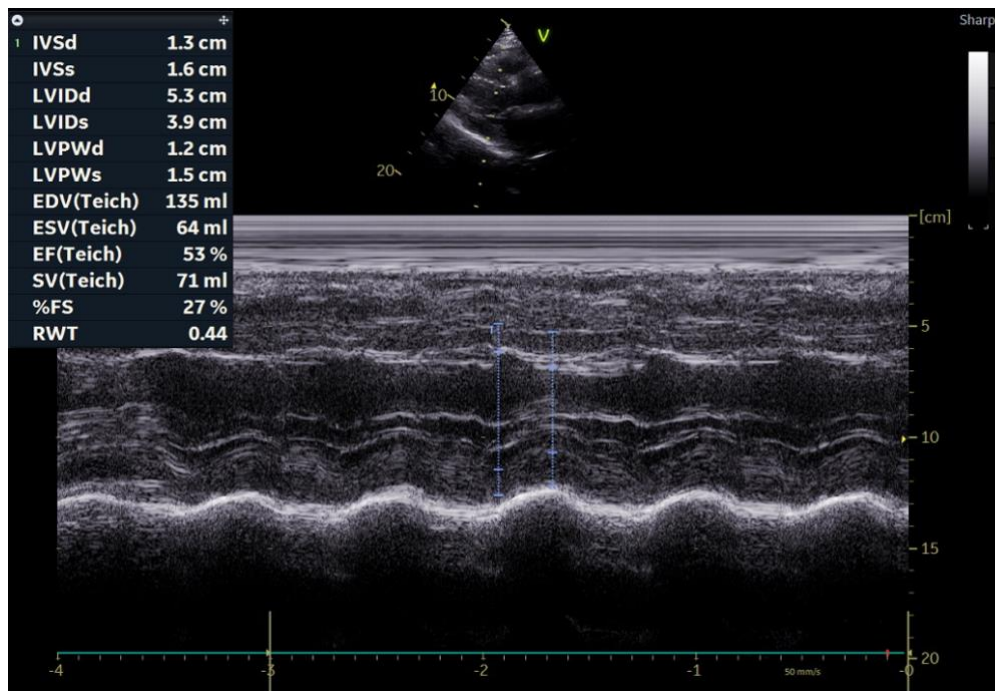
LVIDd, LVIDs, EF (%), LAD, LVPWd, FS (%) measurement during echocardiography (2170 × 1748 cm: 600 dpi).
